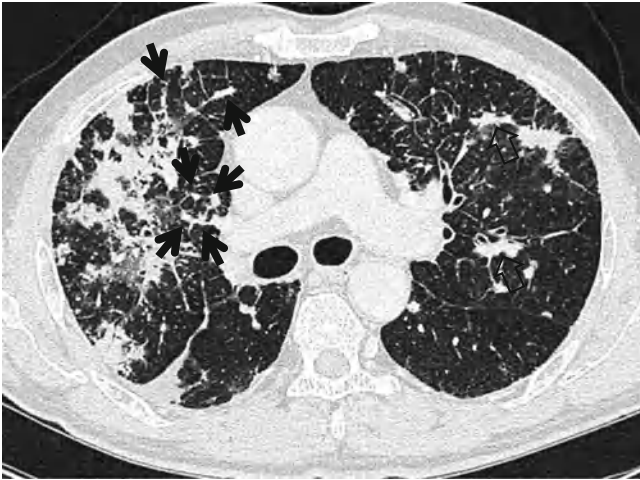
Lung adenocarcinoma and pulmonary lymphangitic carcinomatosis in a 65-year-old man. Thin-section (1.5-mm section thickness) CT scan obtained at subcarinal level shows multiple variable-sized, poorly or well-defined nodules in both lungs. Nodular or band-like interlobular septal thickening (*arrows*) is seen in the right lung. Also note thickened axial interstitium (*open arrows*)
